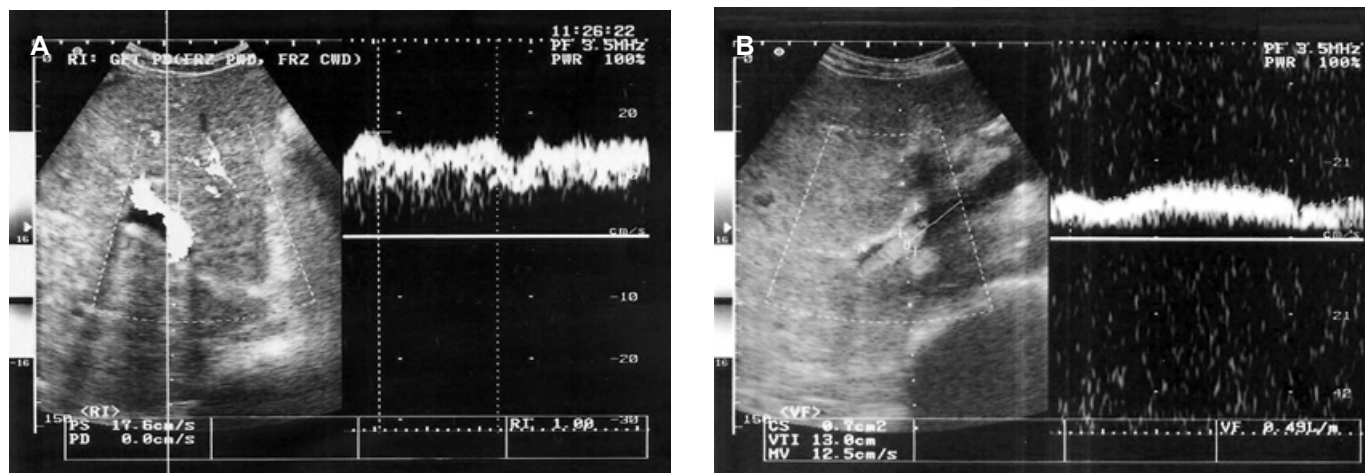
Doppler spectral waveforms of portal vein showing a relatively steady flow throughout its center.
